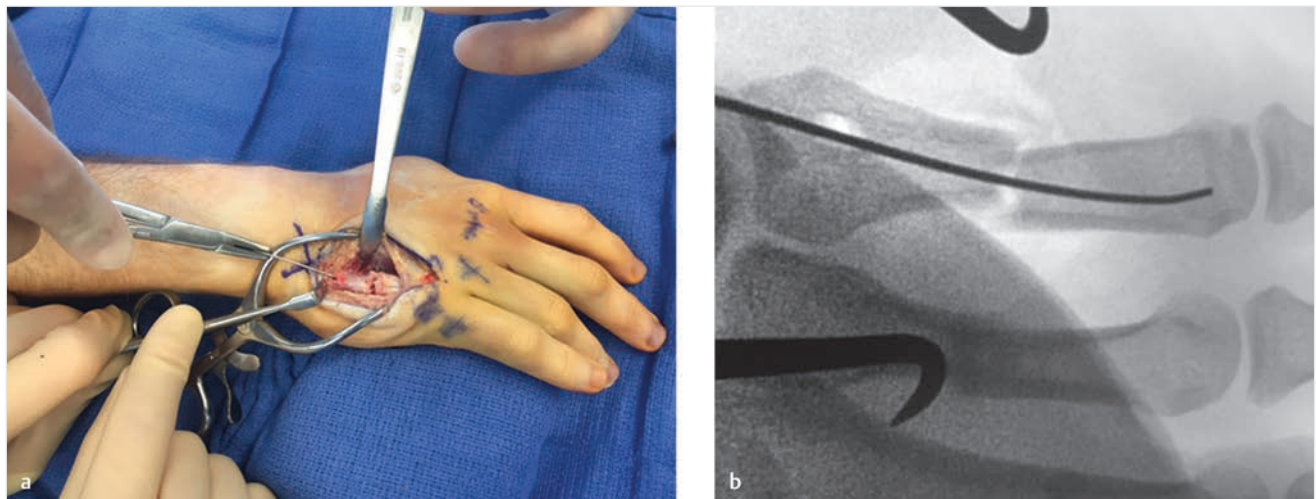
(a) Insertion of the first wire across the fracture site. (b) Radiographic appearance after insertion of the first wire.
